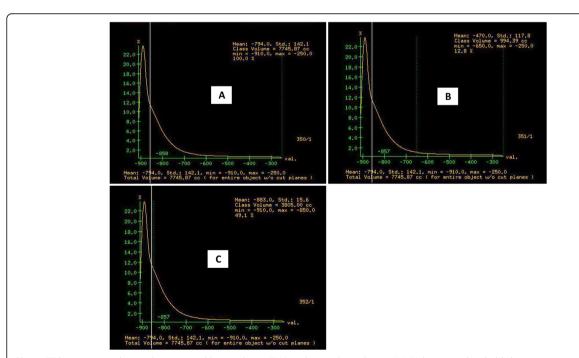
CT histogram analysis a showing total lung volume (TLV) and mean lung density (MLD) between threshold densities – 250 and – 910 HU, b showing the percentage of the lung occupied by high attenuation areas (HAAs %) about 12.8%, and c showing the percentage of lung occupied by low attenuation areas (LAAs %) about 49.1%
